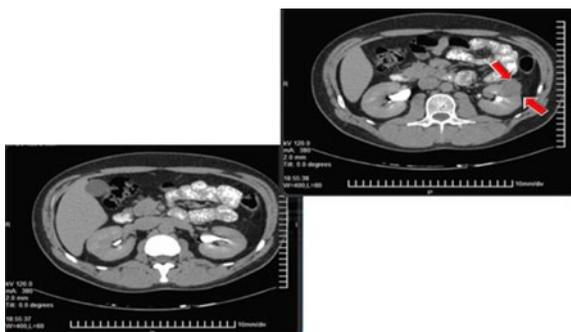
MRI of renal, tumou
